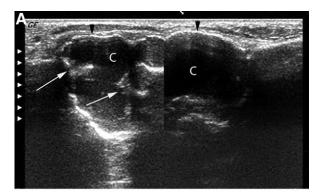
Subject 1: Multilocular. US (A) showed internal bony septa (*arrows*), visualized as strong echo bands; the size of compartments (C) is big and different; the bone cortex appeared as thinning eggshells (*arrowheads*). Panoramic radiography (B) showed it was multilocular and the boundary was clear.
